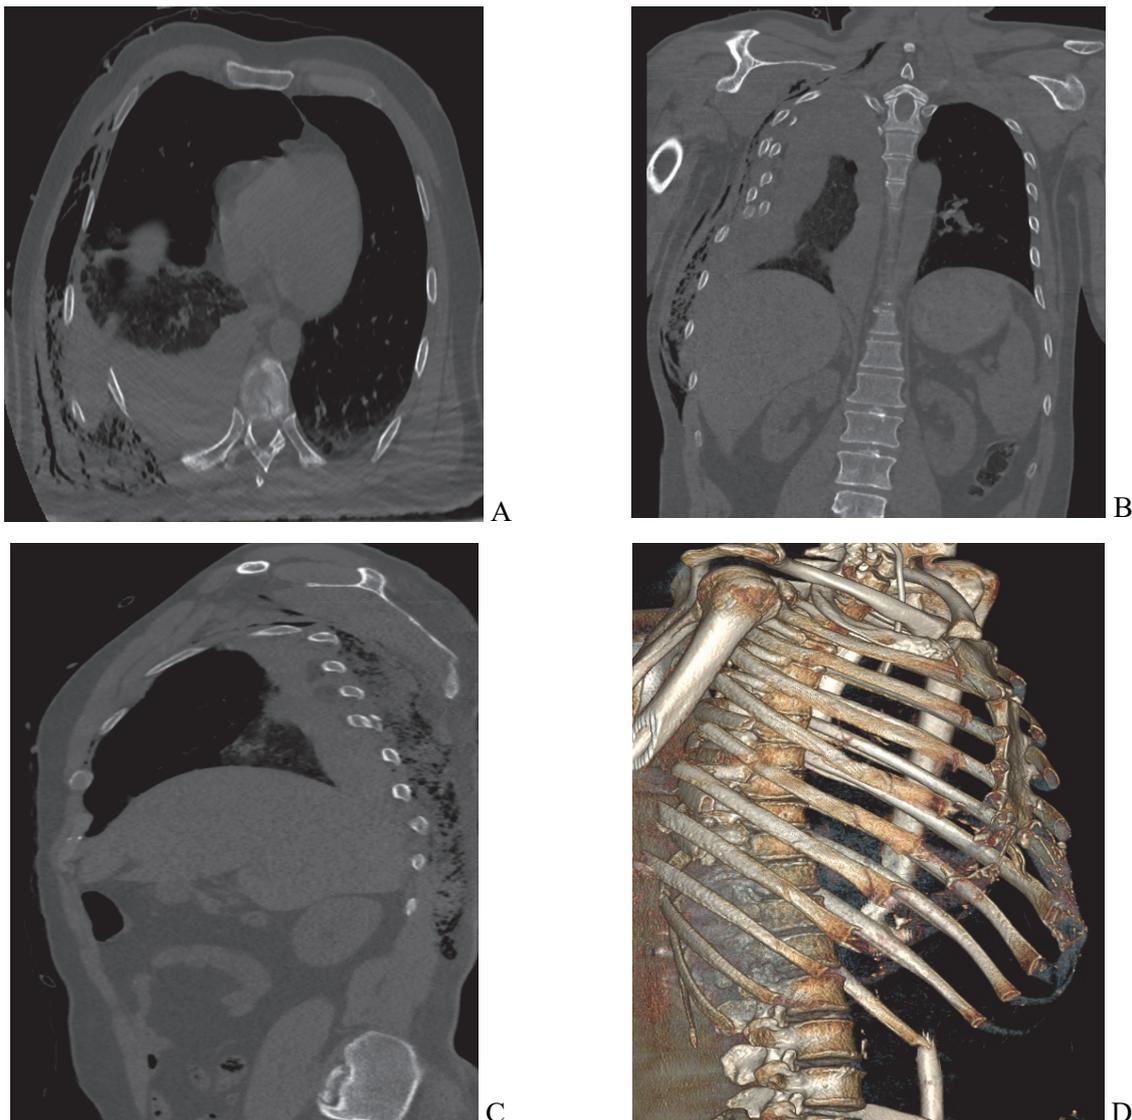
Data of pleural and abdominal cavities multispiral computed tomography of patient L., 49 years. The 1st day after injury: closed fractures of the III-X ribs on the right side (V–VIII ribs – double). Right-sided hemopneumothorax, pneumonitis. Subcutaneous emphysema of the right chest. Free fluid around the spleen: A – axial projection; B – coronal projection; C – sagittal projection; D – 3D modelling.
